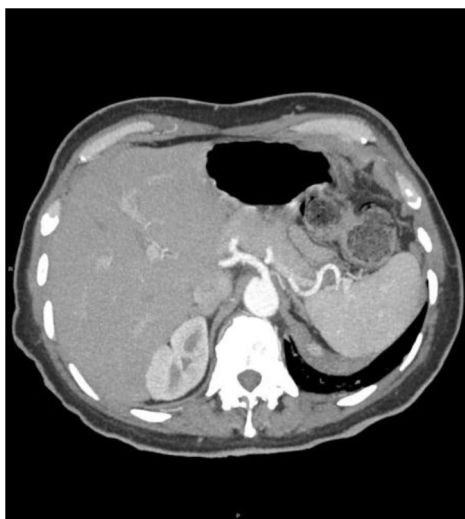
Computed tomography – chest, abdomen, and pelvis from the first admission: No organomegaly, normal abdominal aorta, and diffuse degenerative spine changes.
